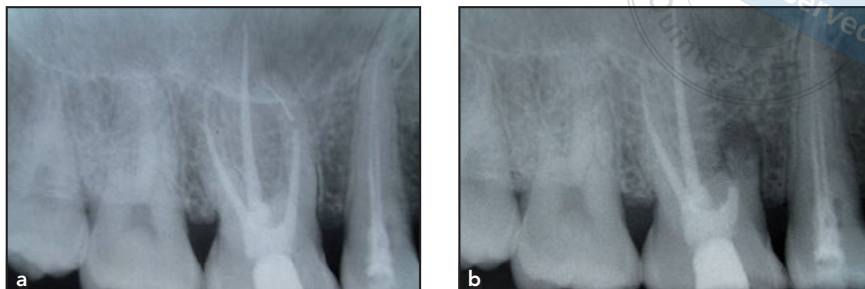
(a) Baseline radiograph showing instrument separation in the mesiobuccal root. (b) Radiograph at 3-month recall showing bone fill in the region of the resected root.
